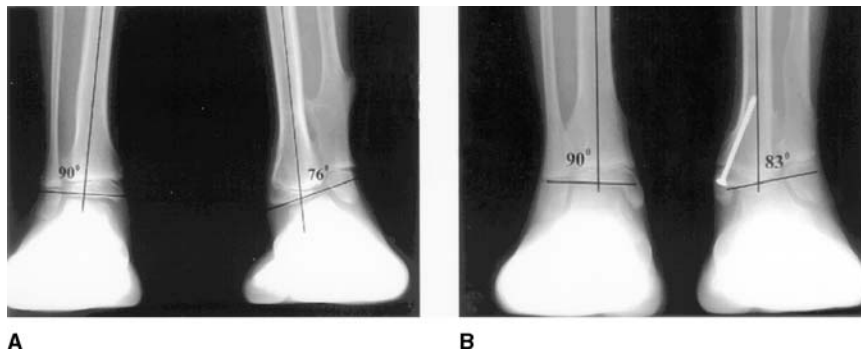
A, Standing anteroposterior radiograph of the ankles of a 7-year-old girl demonstrating left ankle valgus. B, Standing anteroposterior radiograph taken 34 months after surgery. Treatment with a medial transphyseal screw allowed for continued lateral growth to correct the deformity. (Reproduced with permission from Pierz KA, Stieber JR, Kusumi K, Dormans JP: Hereditary multiple exostoses: One center's experience and review of etiology. *Clin Orthop* 2002;401:49-59.)
